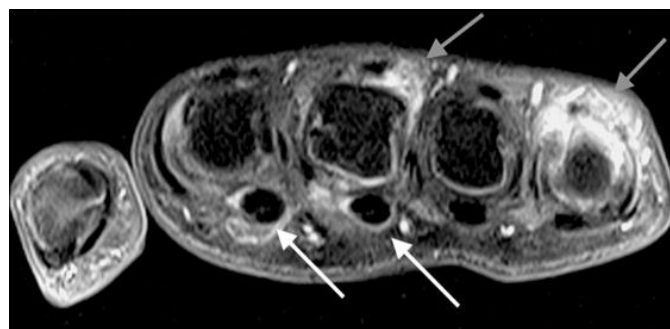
MRI of the left-hand shows T1 post-contrast with fat saturation. Note the enhancement of the flexor sheaths of the second and third digits (white arrows) and of the extensor peritendinous soft tissue of the third and fifth digits (gray arrows).
